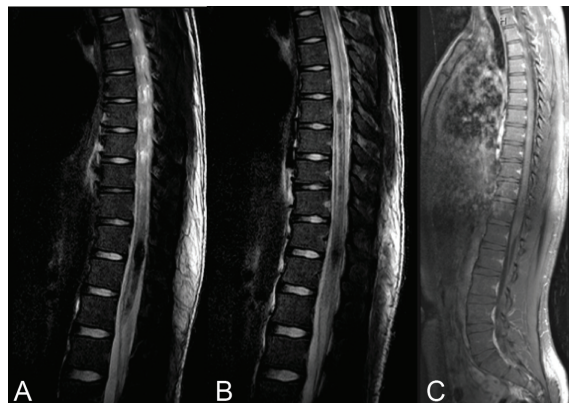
MRI of thoracic spine. A, B) Sagittal T2 weighted images, showing abnormal longitudinal T2 hypointense lesion along lower thoracic spinal cord with spinal cord edema up to T3 level. C) Sagittal T1 weighted postgadolinium images, showing no definite enhancement.
